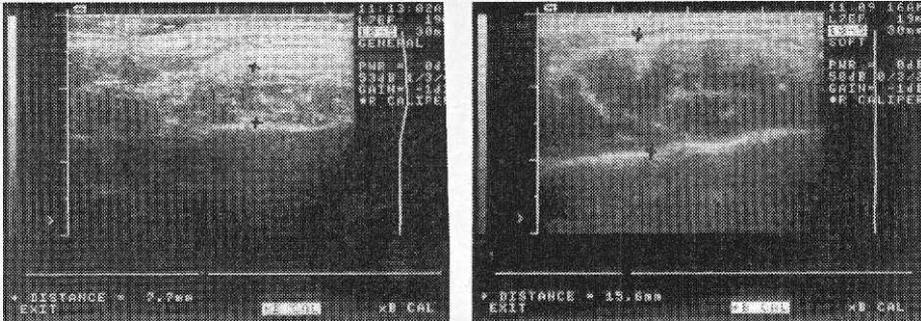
Transverse ultrasound scans of the masseter muscle. The wide white shadow on the top depicts the skin echo. The image of the masseter muscle mass is the darker area under the skin. The tendinous structures are the white stripes in the darker area. Under the muscle, the echo from the bone of ramus is observed as a white stripe. The two crosses point to the location of the electronic callipers used for measuring the thickness of the masseter. To the left is a scan of a thin muscle (7.7mm thick) with small black areas representing muscle mass and blurred tendinous structures. The dark areas are smaller and less distinct than the muscle mass to the right because of an accumulation of adipose cells, which results in a greater intramuscular echo intensity. To the right is a scan of a thick muscle (15.6mm thick) with large dark areas representing the muscle mass and distinct fan-like tendinous structures. The line at the right side depicts the position of the buttons on the control panel of the equipment.
